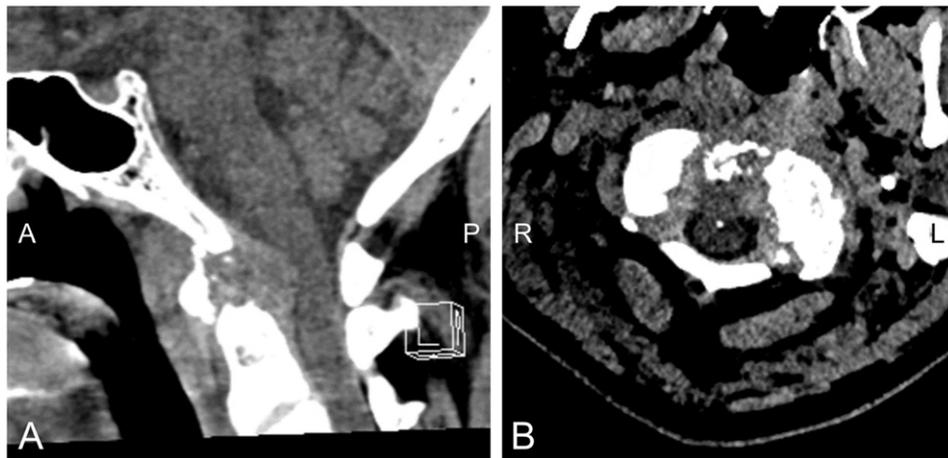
Post-operative CT imaging reveals reduction in lesion size. A) Sagittal view demonstrates a 1.7 × 1.3 cm rim-enhancing lesion and phlegmon in the anterior epidural space at the C1 vertebra causing cervical cord indentation. B) Axial view demonstrates cervical cord indentation at the C1 vertebra, paracentral laminectomy of the anterior arch of C1, and partial resection of the right aspect of the dens.
